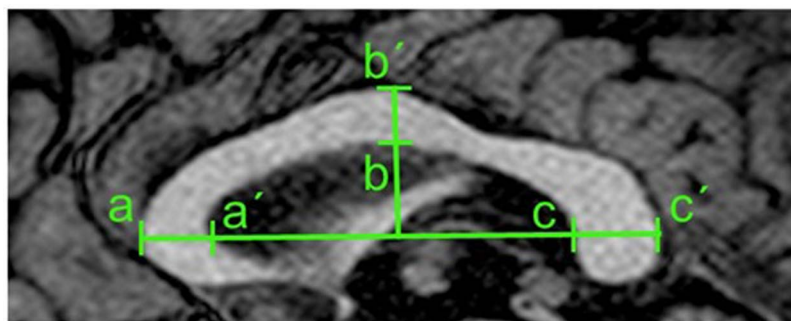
Corpus Callosum Index (CCI) measurements. CCI is calculated by summing the antero-posterior length of the genu and the splenium and the cranio-caudal height of the body of corpus callosum, divided by the length of the CC. Annualized CCI atrophy rate (%) is calculated: first MRI CCI minus second MRI CCI, and dividing by the first MRI CCI, multiplying for 100, and annualizing using the time between the two MRI.
